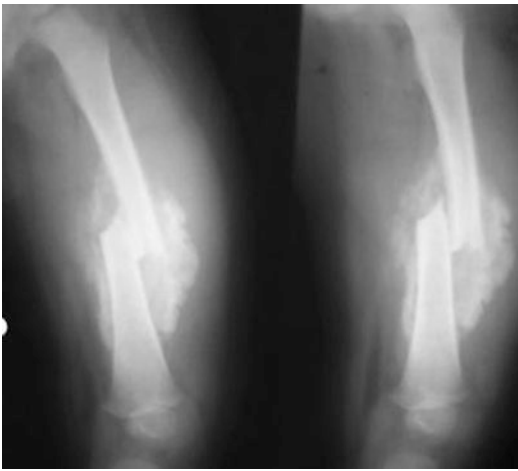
X-rays of malunited fractured femur on 12th day after the injury
